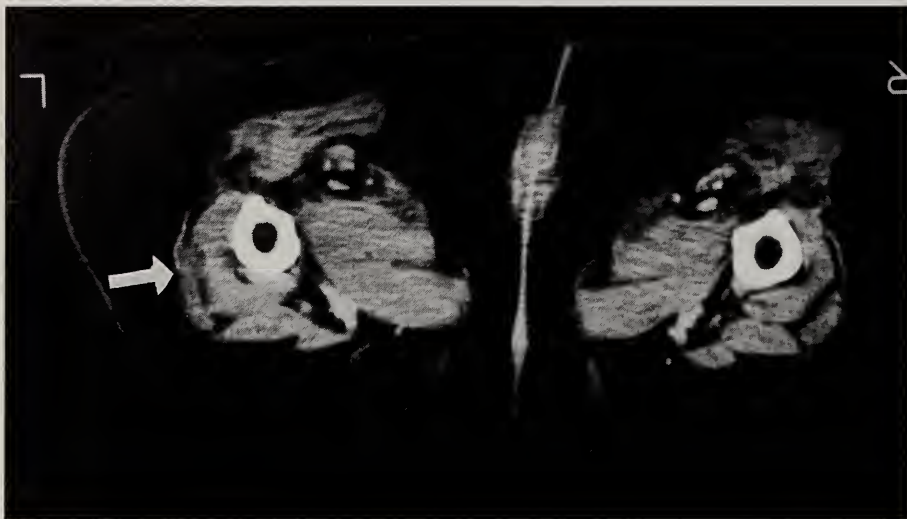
CT scan of both legs demonstrating multiple fluid collections enhanced by dye at several levels.
